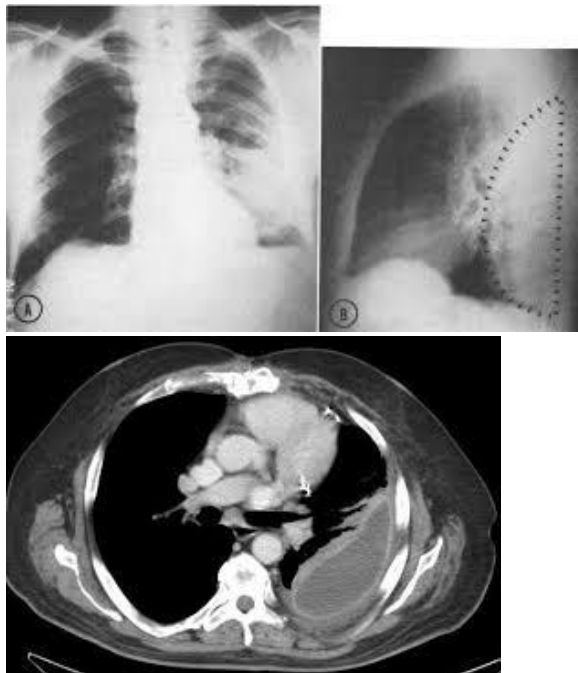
radiological studies A- Lateral X-ray of empyema. This film shows the D-shaped outline of a typical empyema. Infected fluid collections can, however, occur anywhere within the chest. B- PA chest X-ray of a patient with empyema, showing opacity in the lower left zone. C- CT scan of a patient showing a posterior collection of pus in the left lung.
